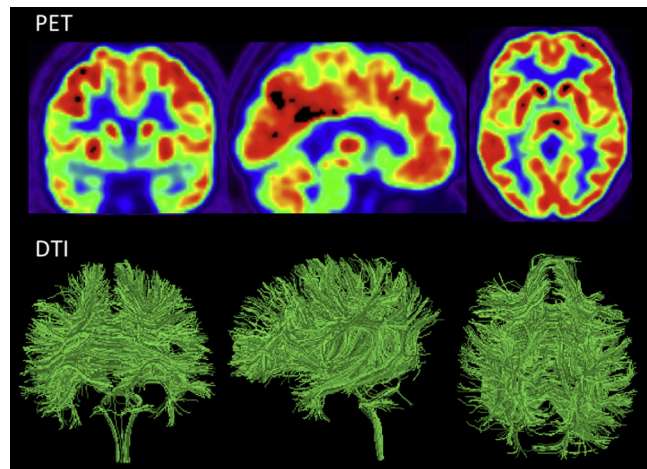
FDG-PET brain metabolism uptake and diffusion tensor imaging (DTI) in healthy subjects. Transaxial, sagittal, and coronal views. Note the most intense uptake is in the precuneus and striatum followed by the thalami and the occipital cortex. DTI shows the white matter tracks in the brain and brainstem of a healthy subject.
